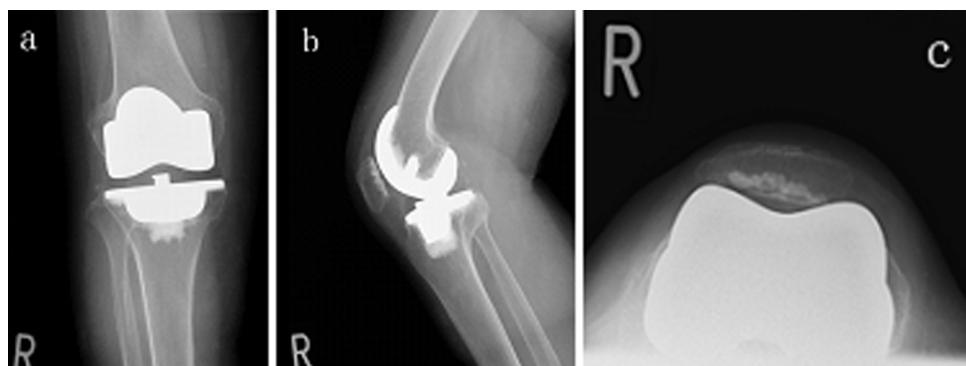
Post-operative X-ray images of the right knee (case 1) Radiographs of the right knee with TKA (Zimmer, NexGen, CR-flex). a. Anteroposterior view. b. Lateral view. c. Skyline radiograph view.
